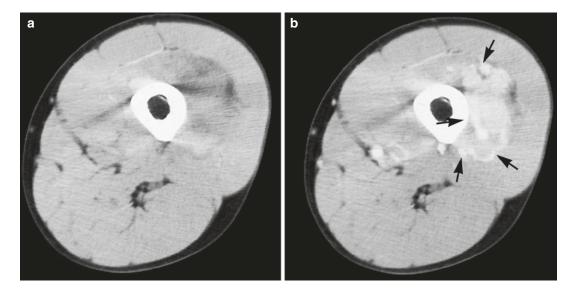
Alveolar soft part sarcoma of the left thigh in a 26-year-old man. (a) Plain CT. (b) CT after iodinated contrast injection. The presence of a soft tissue mass at the lateral aspect of the femur with unsharp delineation from adjacent vastus intermedius and lateralis muscles. On
